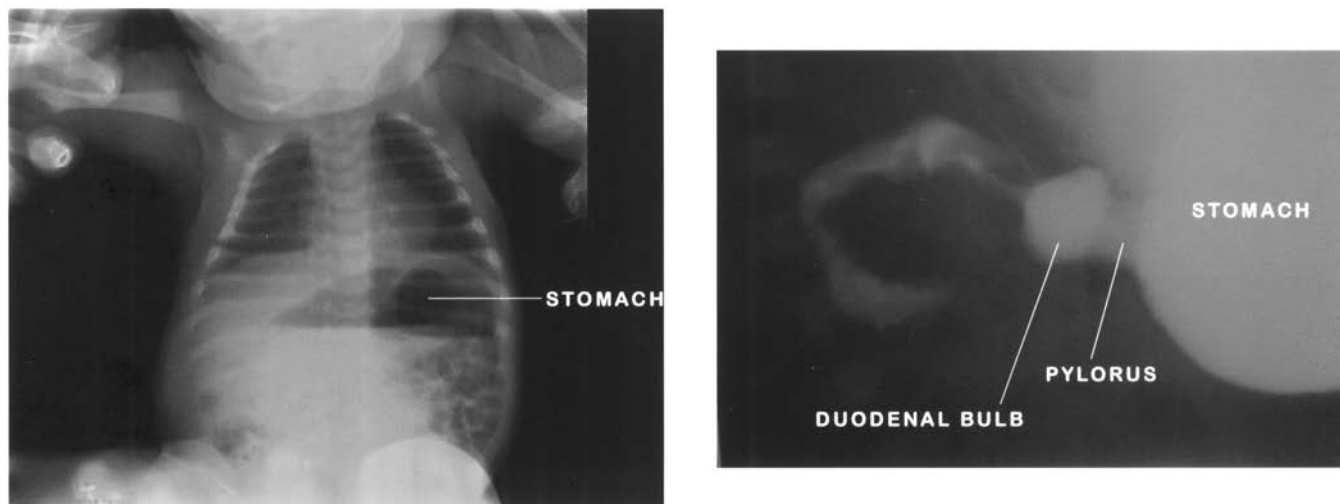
Abdominal x-ray on the left demonstrates a dilated air-filled stomach with normal caliber bowel, consistent with gastric outlet obstruction. Barium meal figure on the right confirms diagnosis of pyloric stenosis. The dilated duodenal bulb is the “olive” felt on physical exam. Note how there is a paucity of contrast traveling through the duodenum. (Used with permission from Drs. Julia Rosekrans and James E. Colletti.)
